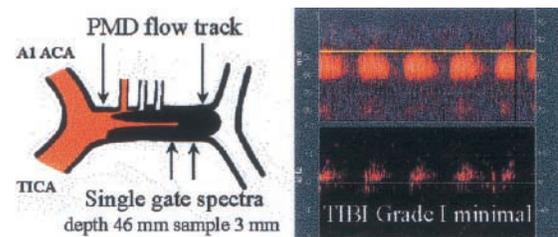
Middle cerebral artery (MCA) high-resistance flow signature and the residual flow signals at the clot location. An 80-year-old man had a total National Institutes of Health Stroke Scale score of 15 and confirmed proximal M1 MCA occlusion at digital subtraction angiography (see Fig 7). Power motion mode Doppler (PMD) shows a high-resistance MCA flow track with absent end-diastolic flow. A single-gate transcranial Doppler spectra shows a Thrombolysis in Brain Ischemia (TIBI) minimal flow signal at a depth of 46 mm. PMD flow tracks also indicate that this flow pattern is present through the M1 stem at depths of 45 to 62 mm. ACA = anterior cerebral artery, TICA = terminal internal carotid artery.
